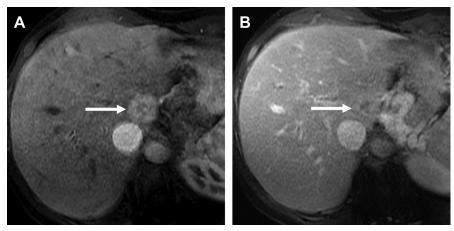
A 25-year-old boy with history of chronic portal vein thrombosis with cavernous transformation. Axial contrast-enhanced MR imaging obtained during hepatic arterial phase (*A*) shows arterially enhancing lesion (*arrow*) with central scar. The lesion became iso-intense to the background liver on equilibrium phase (*B*). The lesion was stable for 3 years consistent with benign etiology. Of note, this lesion was new compared with prior examinations (not shown).
